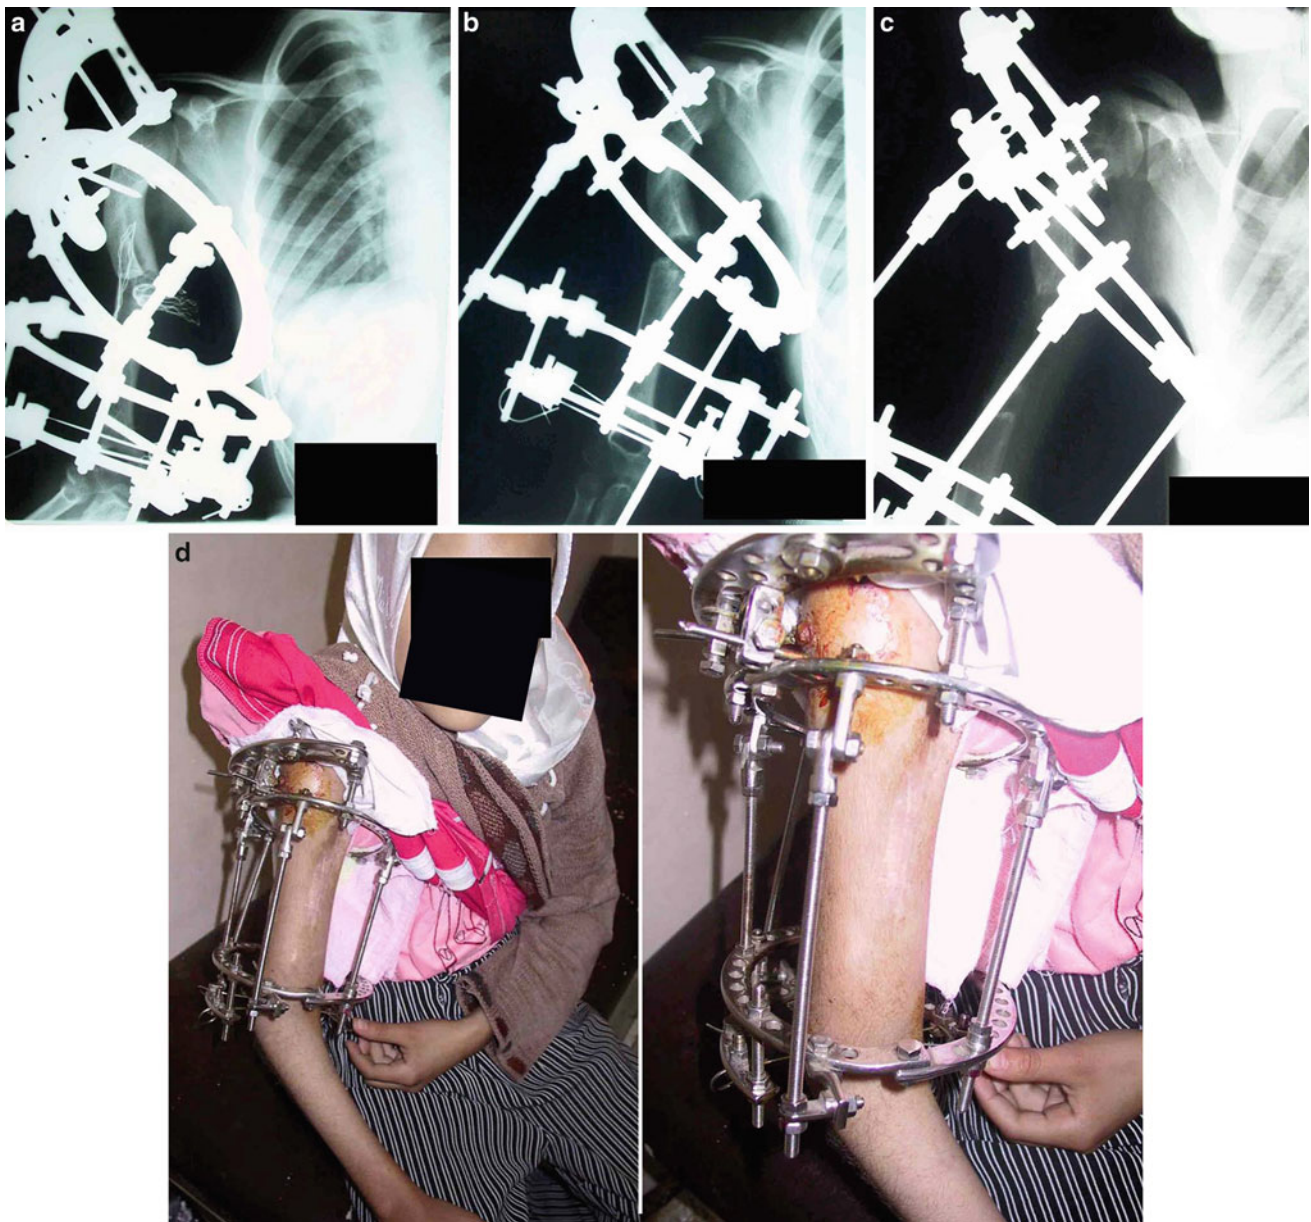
(a) Immediate postoperative radiograph. (b) Radiograph during distraction showing correction of the deformity. (c) Radiograph at the end of lengthening. (d) Photos at the end of lengthening
